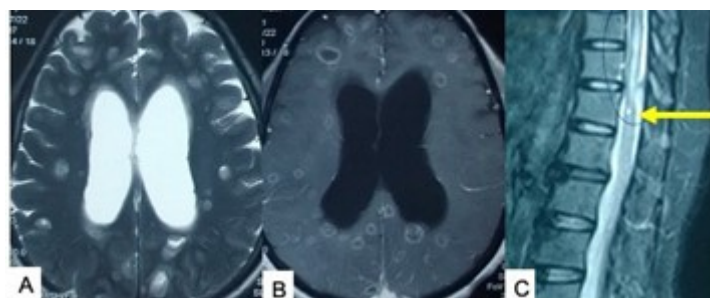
(A,B) MRI of the brain showing extensive neurocysticercosis. (C) MRI of the spine of the same patient showing neurocysticercosis in the spinal cord. Source: Figure by authors.
